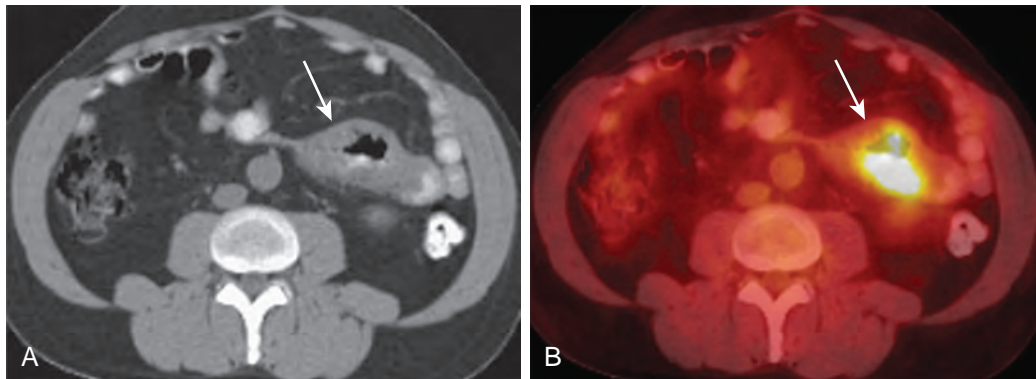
Post-transplantation lymphoproliferative disease. A. CT shows focal thickening of proximal jejunum 3 years after transplantation (arrow). The patient presented with melena. B. CT/PET shows that the segment is markedly FDG avid (arrow).
